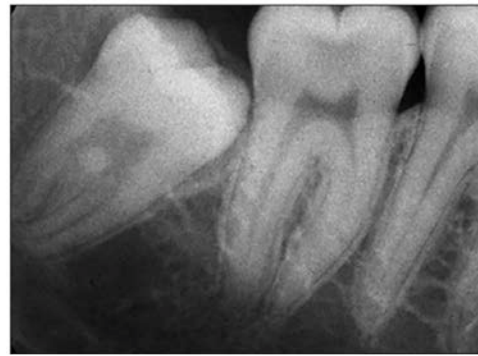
Periapical radiograph of #32 with a furcal enamel pearl.
